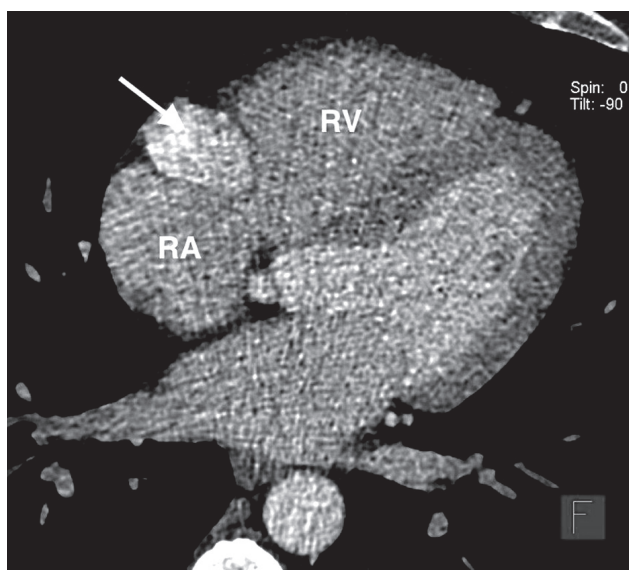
Cardiac CT angiography, multiplanar reconstruction (MPR) axial view shows a hypervascular tumor located in the right atrio-ventricular groove (arrow)
